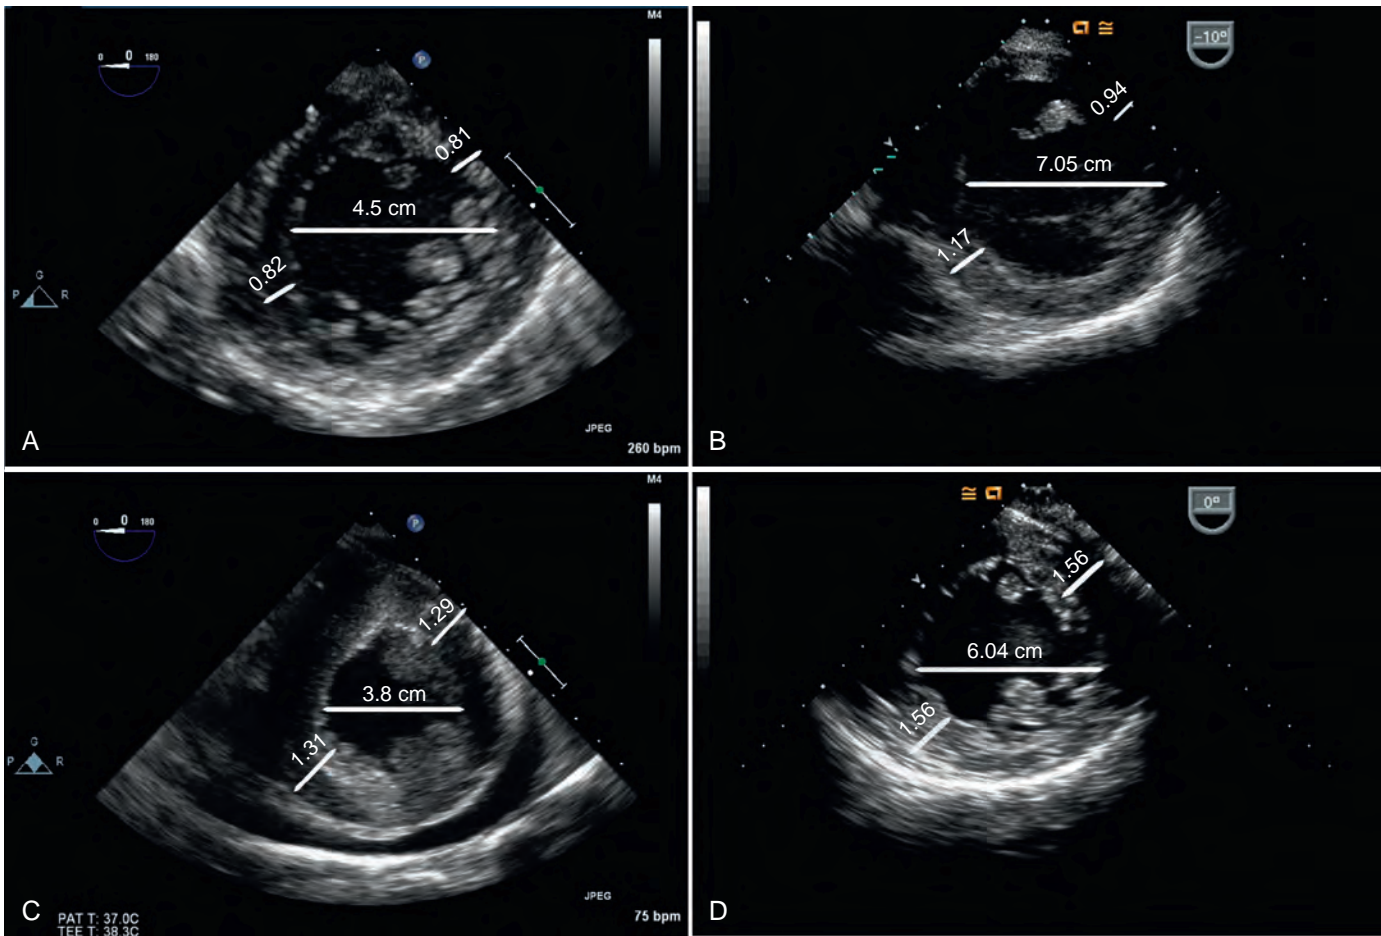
Transesophageal echocardiographic images of the four patterns of left ventricular geometry. (A) Normal. (B) Eccentric hypertrophy. (C) Concentric remodeling. (D) Concentric hypertrophy. (From Weiner M, Kahn RA, Evans AS. Transesophageal echocardiographic assessment of left ventricular mass. *Anesth Analg*. 2015;121:323–328.)
